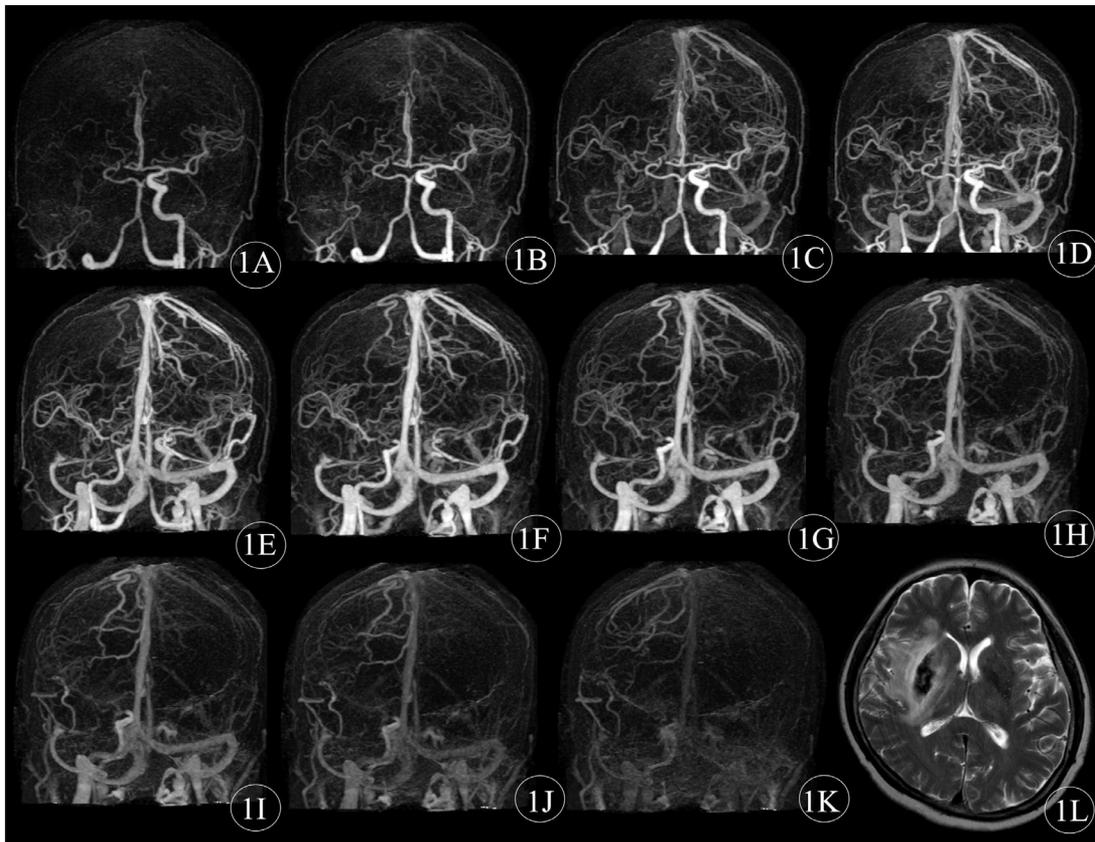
Good collateral case. One 68-year-old female patient suddenly suffered from deviated mouth, inarticulate speech and inability to lift left upper limb for 6 hours. She had an initial NIHSS score of 15 and a mRS score of 1 after 3 months. 4D CTA (1A-1B) showed occlusion of the whole right internal carotid artery (ICA) and right middle cerebral artery (MCA), but on delayed phase images (1C – 1H), the majority of the right ICA was well developed. Thus, the patient got a 4D CTA collateral circulation score of 3, and a sCTA (1B) collateral circulation score of 1. The T2WI on day 6 (1L) showed acute infarct lesions with hemorrhage.
